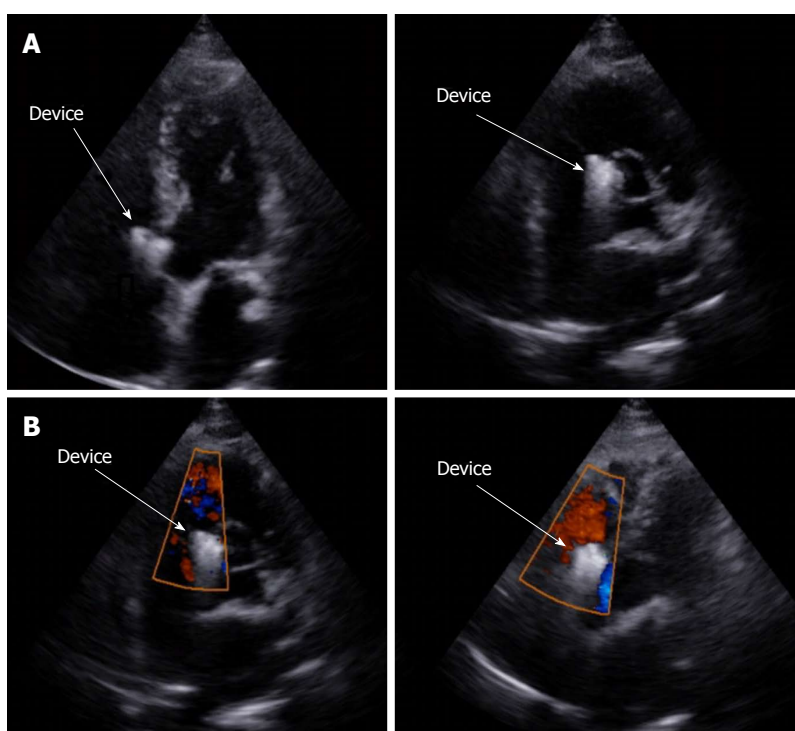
Six months following up showed steady result with good device position and no shunt on echocardiography. A: Transthoracic echocardiography performed 6 mo after the procedure showed good device position at apical five chamber view (left) and parasternal short axis view (right); B: Colour doppler showed no residual shunt at apical five chamber view (left) and parasternal short axis view (right) 6 mo after device deployment.
